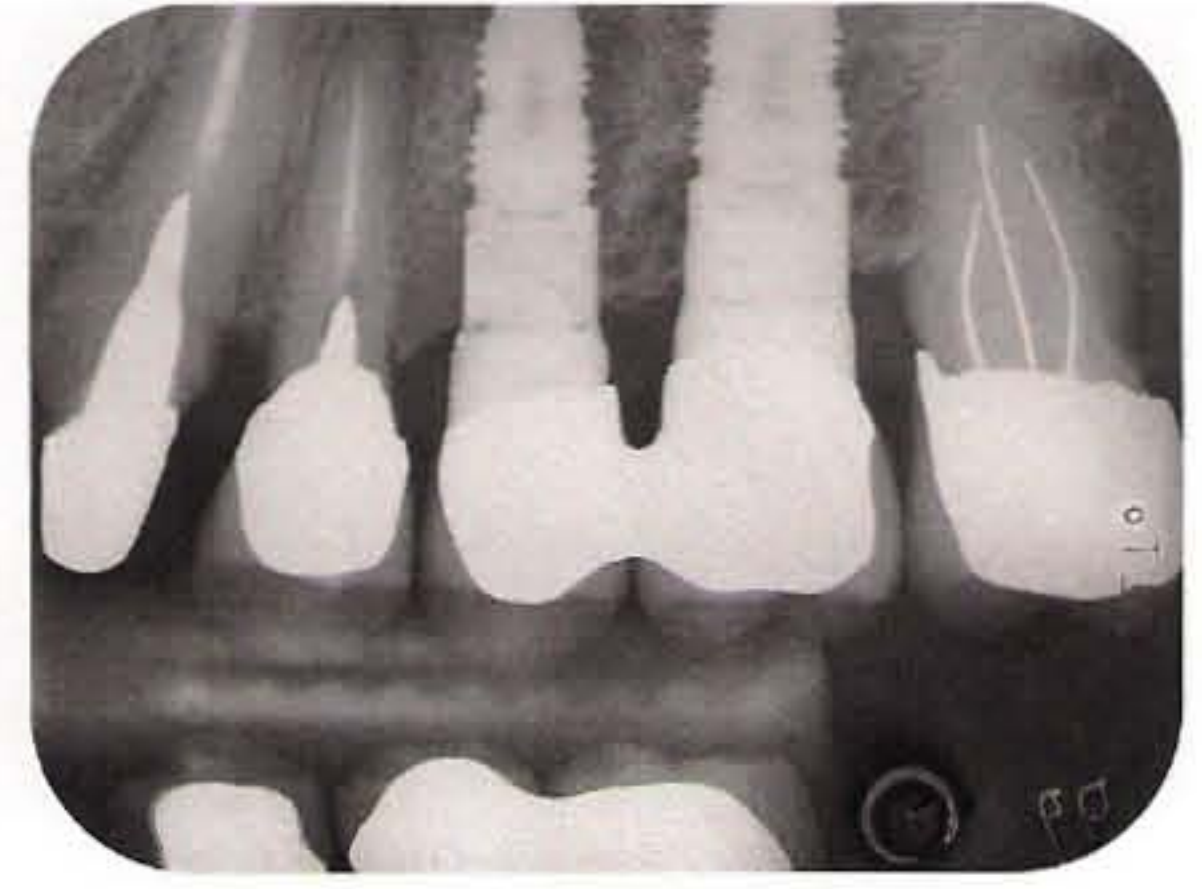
Control radiograph taken after loading of the prosthesis.
